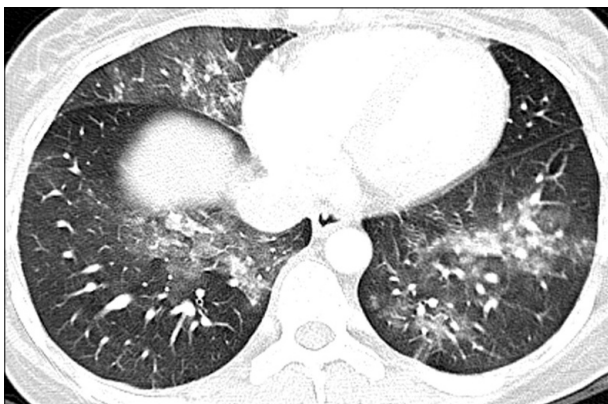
Chest computed tomography scan shows patchy ground-glass opacities in the right-middle lobe, both lower lobes, and a small portion of the right-upper lobe.
